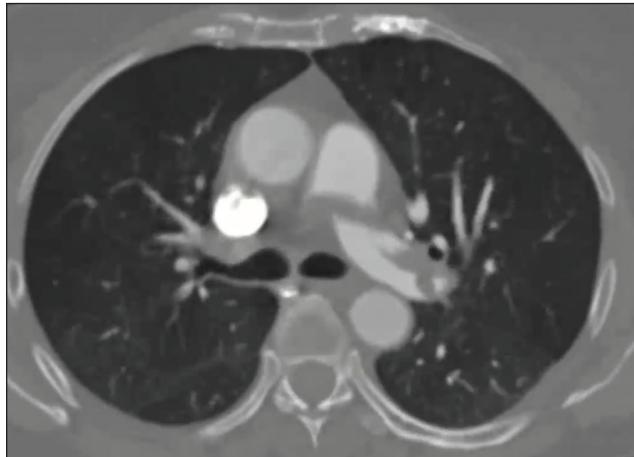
CT image showing saddle clot and significant clot burden extending into the right and left PAs.
